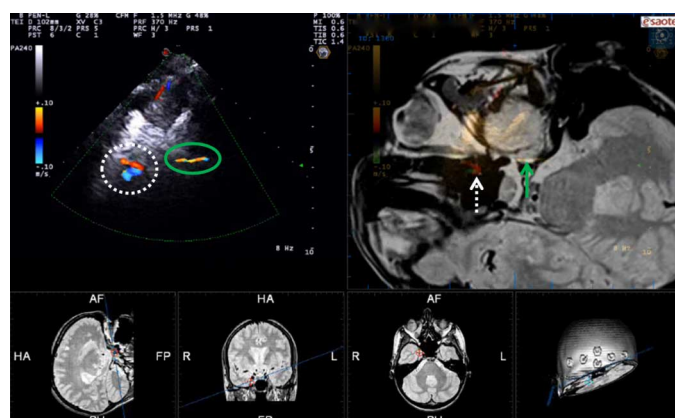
An example of false signal and true signal (Superior petrosal sinus) in the same frame, and their anatomical position visualized on MRI. (a) US image with dotted and continuous circles pointing the false and the true signals respectively, (b) fused US and MR image with dotted and continuous arrows pointing the false and the true signal positions. The signal position has been pointed with a mark in the sagittal (c), coronal (d), axial (e) and oblique (f) sections.
